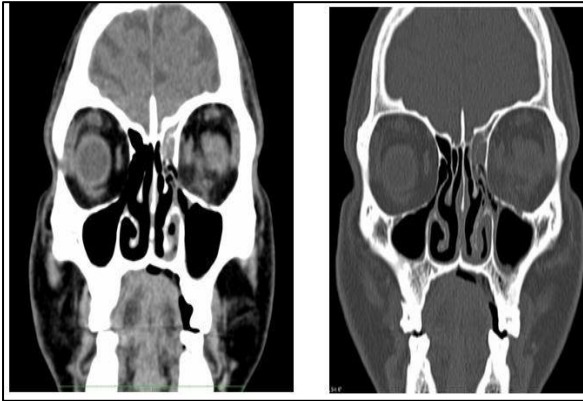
CT scan of paranasal sinuses.
